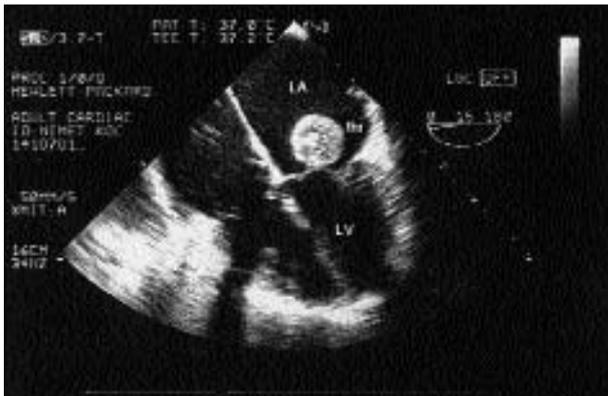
Transesophageal echocardiography of FFLABT in patient's second admission.
